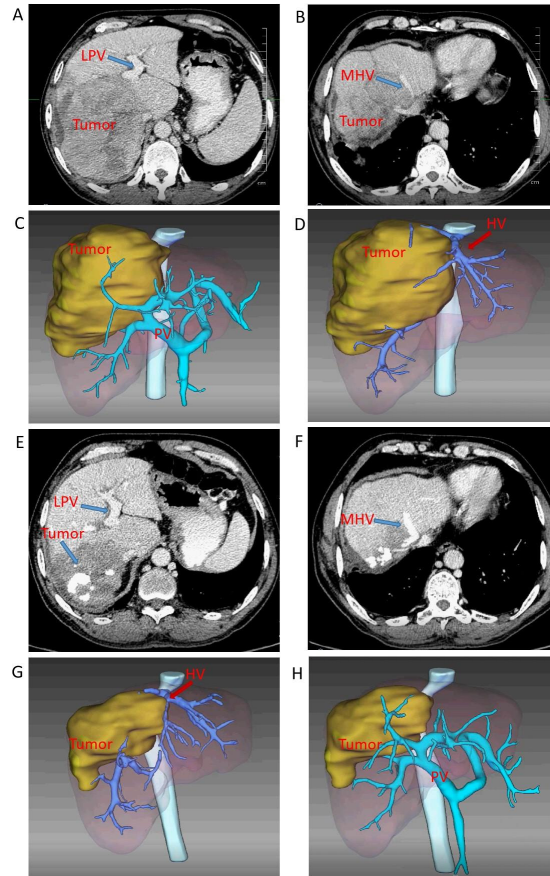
Enhanced CT before operation showed that the tumor was enhanced in venous phase and invaded the right branch of portal vein, right hepatic vein and middle hepatic vein, and the 3D reconstruction further determined the relationship between the tumor and portal vein and hepatic vein (A, B, C, D); Enhanced CT before operation showed that the enhancement of the tumor was weakened, the tumor volume was reduced, and the tumor was far away from the right branch root of portal vein (E, F, G, H). LPV: Left hepatic portal vein. MHV: Middle hepatic vein.
